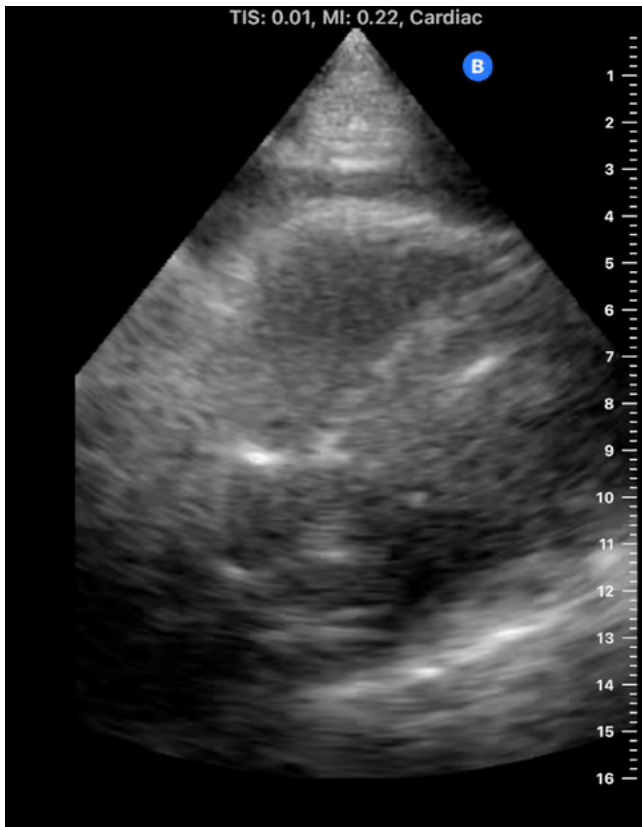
PLEURAL EFFUSION ON ECHOCARDIOGRAM.
